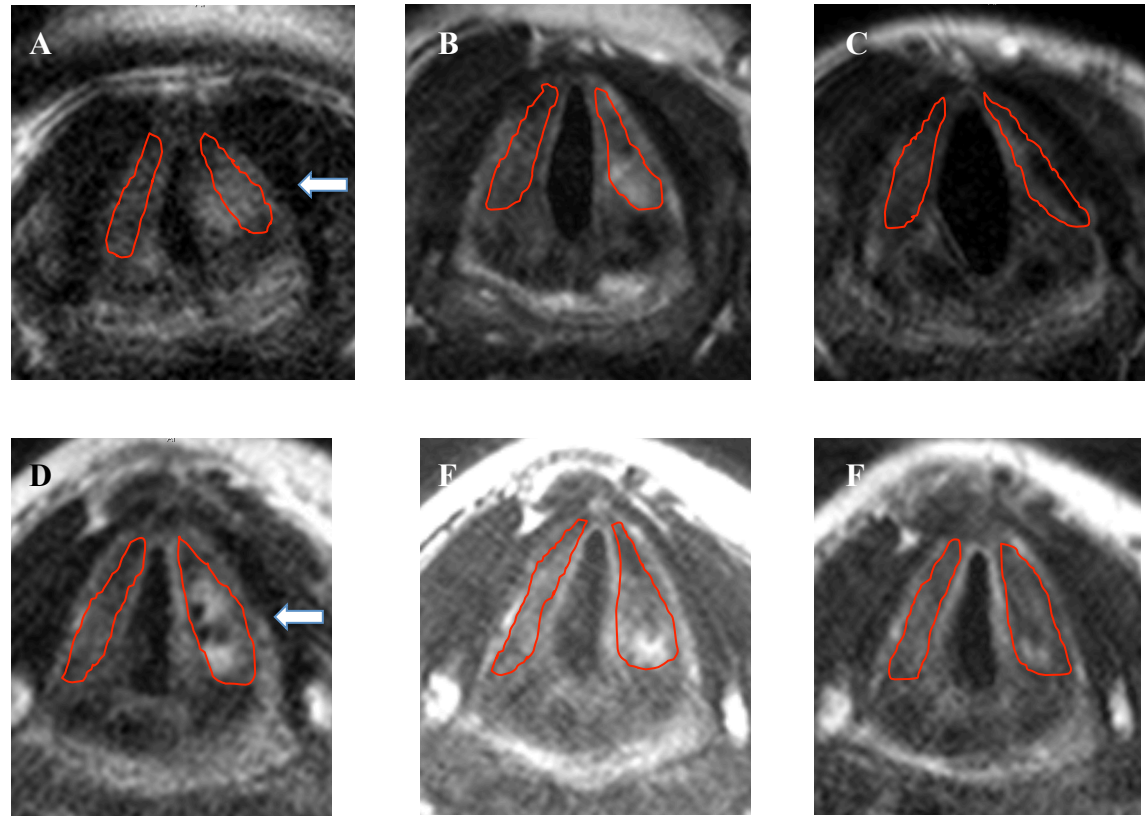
Patient-1 (top row) and patient-2 (bottom row), T2-MRI showing signal intensity changes on the left TA muscle at baseline (A,D); 6- (B,E); and 12-months (C,F) following the reinnervation. The arrow shows the left TA.
